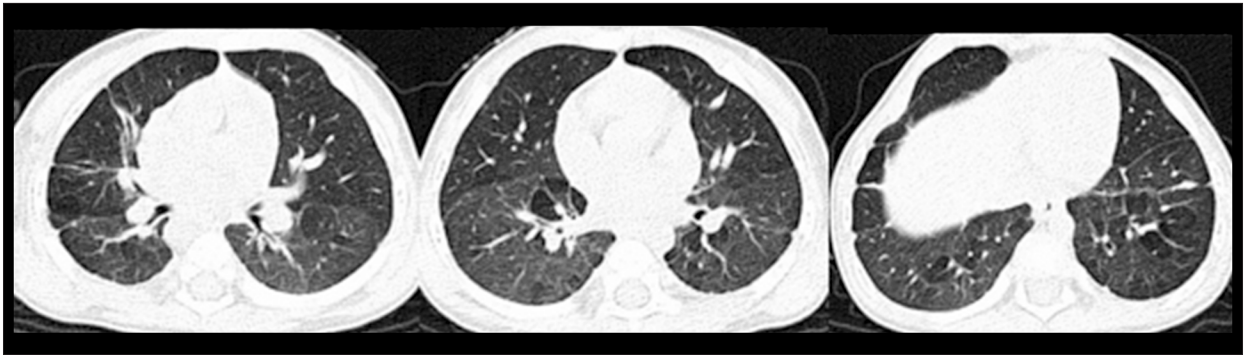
Chest CT after mononuclear cells transplantation.
